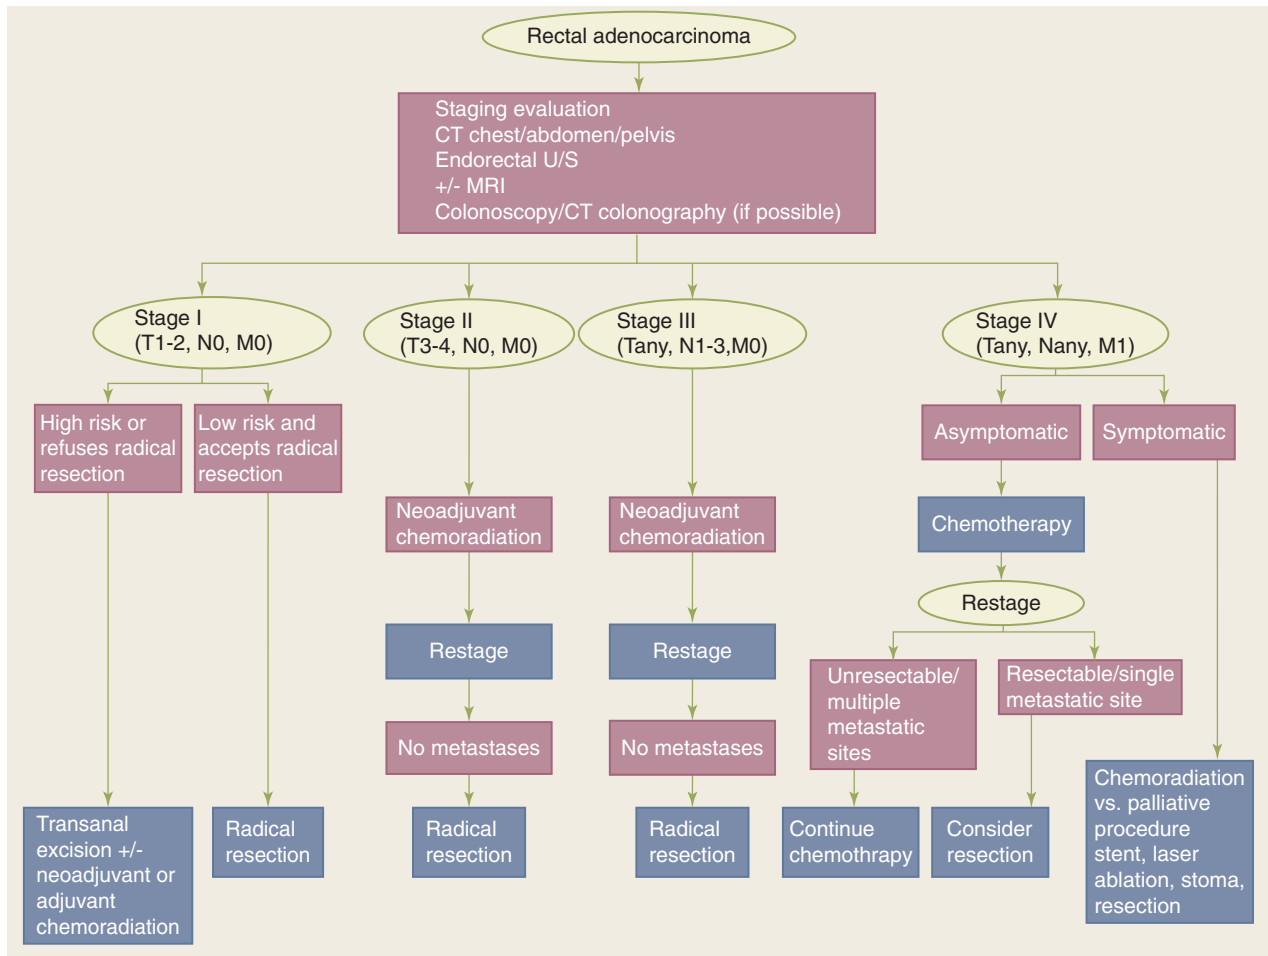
Diagnostic algorithm for rectal cancer. CT = computed tomography; MRI = magnetic resonance imaging; U/S = ultrasound.
